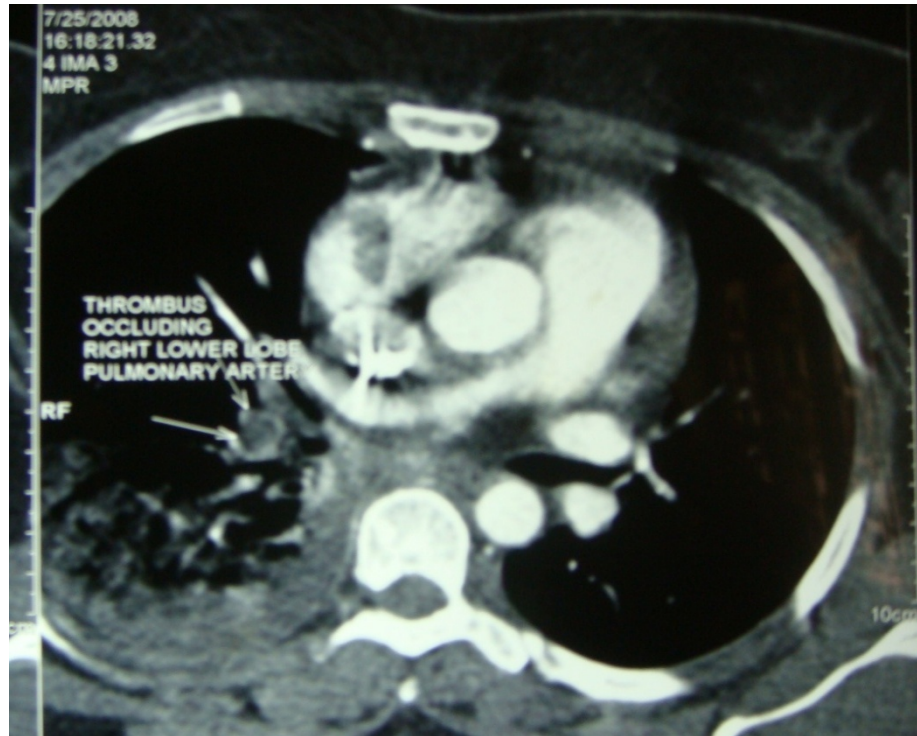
CT Pulmonary angiography: revealing a Large thrombus occluding Rt lower lobe pulmonary artery with Lower lobe pulmonary infarction and Rt pleural effusion.
